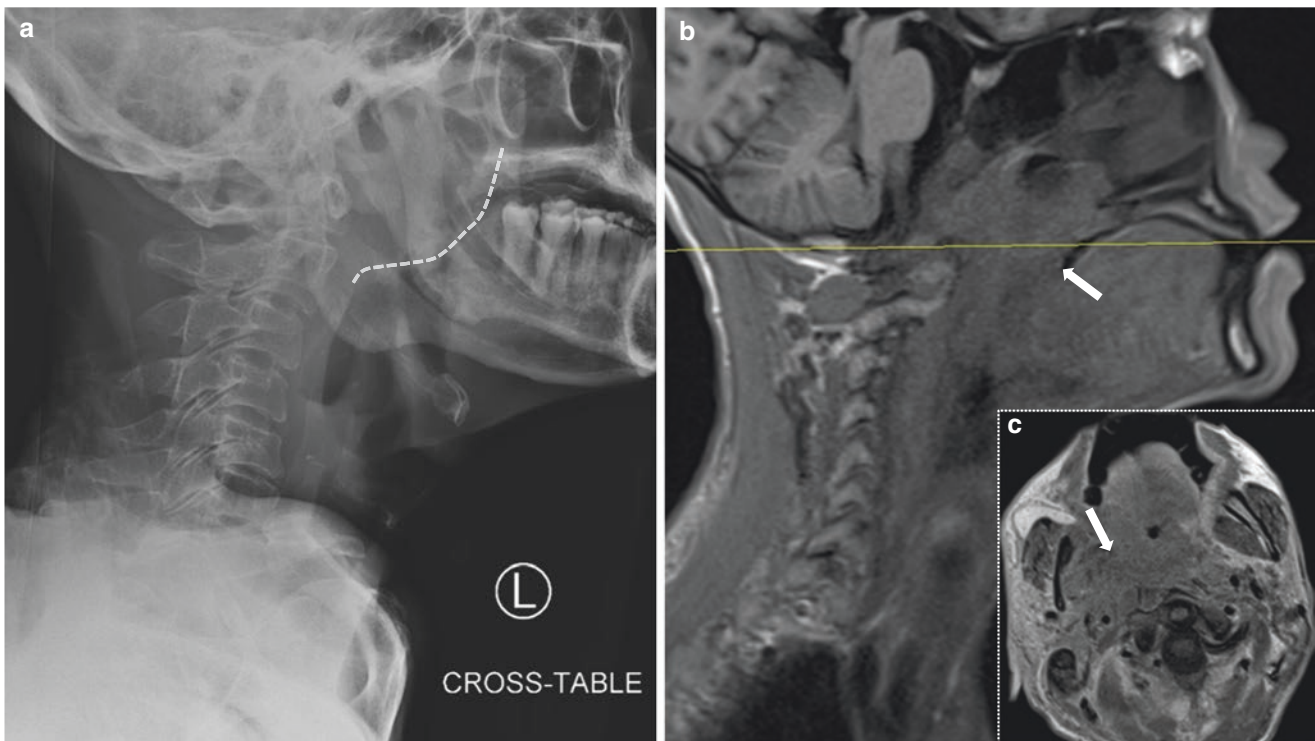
Nasopharyngeal carcinoma. (a) Lateral neck radiograph with an incidental mass (dashed line) filling the posterior nasal space, (b) Sagittal T1 FLAIR, and (c) axial T1 post contrast images confirm a large nasopharyngeal carcinoma (solid arrow) invading the deep neck spaces
